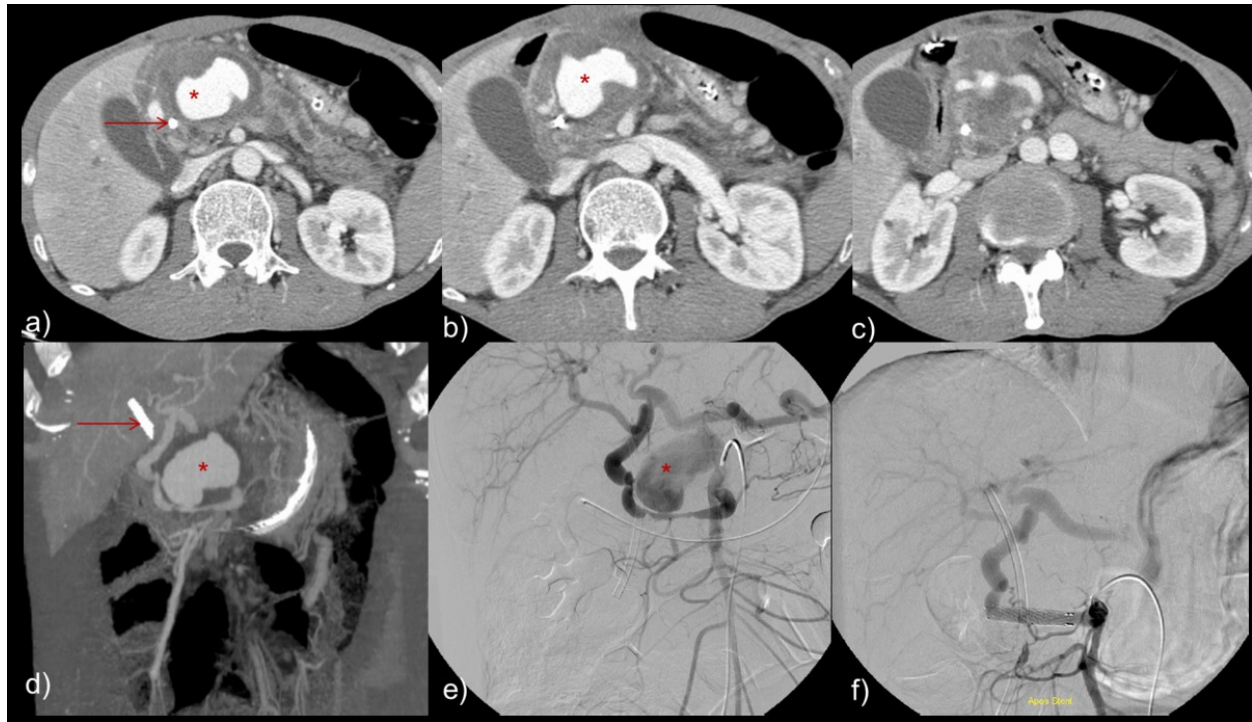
Enhanced axial CT arterial phase images a), b) c) of a 53 year old male patient with severe chronic pancreatitis with a plastic biliary stent (arrows) and a large gastroduodenal pseudoaneurysm (*). Thick coronal MIP image d) demonstrated a narrow neck and a covered stent was deployed via the pancreatico-duodenal inferior artery with successful exclusion of the aneurysm e) and f).
